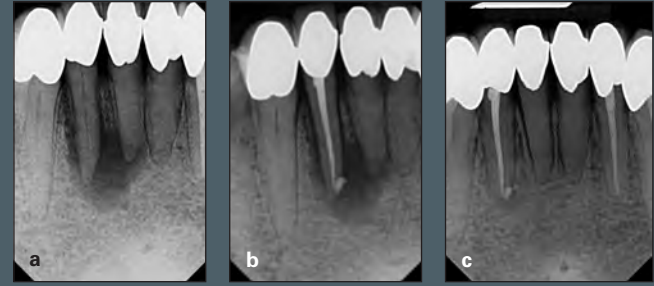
(a) Preoperative view of periapical pathosis. (b) Following endodontic treatment with biocompatible bioceramics. (c) Postoperative view of complete resolution of periapical pathosis.
